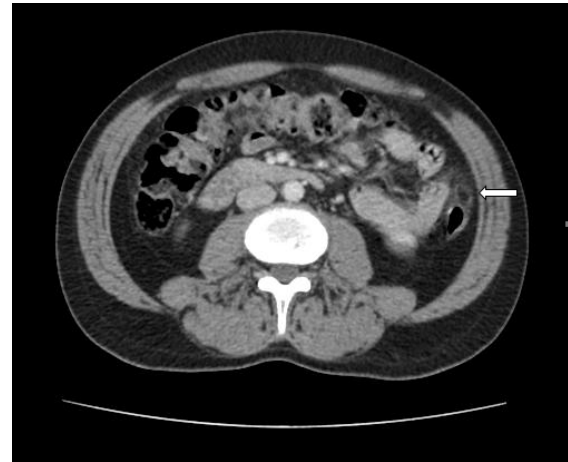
In axial CT scans with intravenous contrast, epiploic appendagitis is seen at the level of the descending colon. Hyperattenuated ring sign observed around inflamed fat tissue (arrow).
